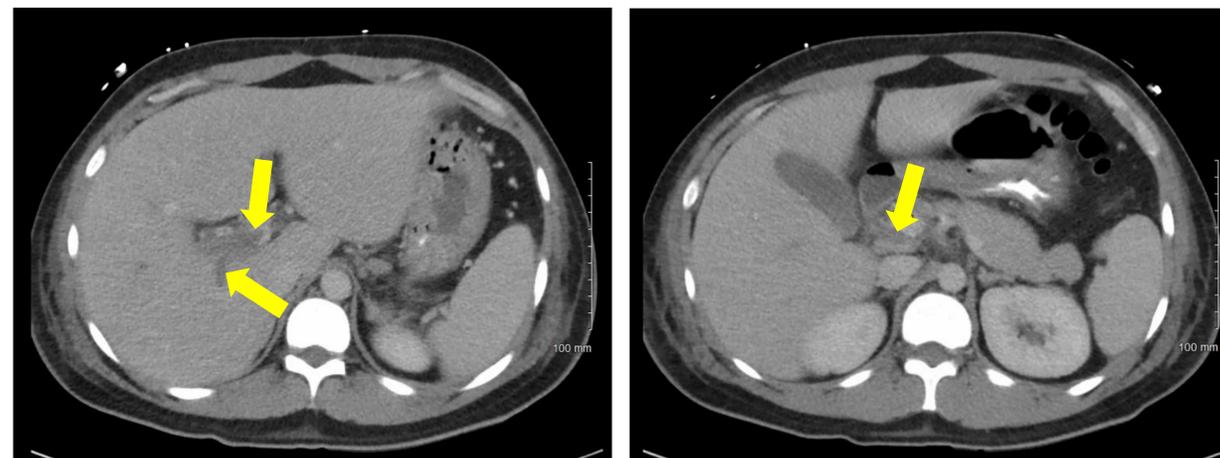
CT Images reveal propagation of superior mesenteric vein thrombosis to the portal vein.
